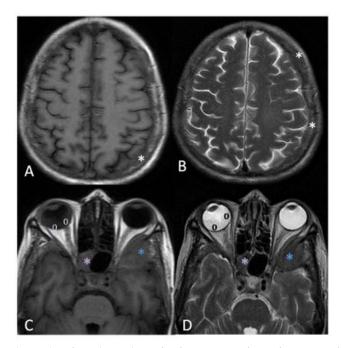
Axial sections from T1 (A & C) and T2 (B & D) weighted images MRI brain depicting well-defined, hypointense masses in the calvarium (white asterisk), greater wing of left sphenoid with extra-dural and extra-conal components (blue asterisk), clivus and right lateral wall of the sphenoid sinus (purple asterisk). In the right orbit, there is a V-shaped membrane showing fluid signals on T1 and T2WI, in the posterior segment attached posteriorly to the optic disc, suggestive of retinal detachment (black and white circles).
